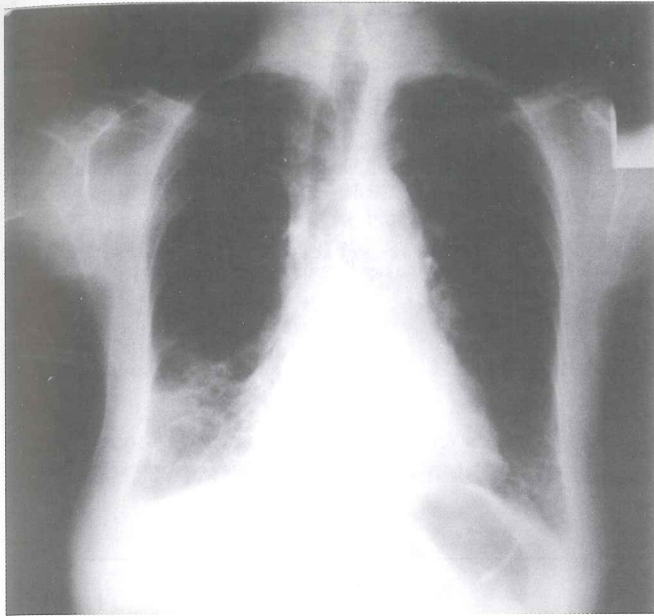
Chest x-ray and thorax CT after chemotherapy. Significant regression is observed in lesions.
